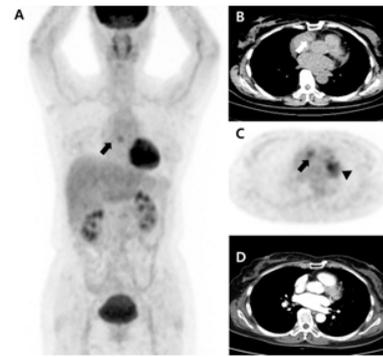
A) Maximum intensity projection image of ^{18}F -FDG PET/CT shows a focal ^{18}F -FDG uptake in mid-chest (black arrow). B, C) Axial ^{18}F -FDG PET/CT shows a nodular soft tissue lesion with mildly increased ^{18}F -FDG uptake adjacent to the right proximal aorta (white and black arrows). Focal ^{18}F -FDG uptake at left side mediastinum is physiologic uptake of left cardiac ventricle (black arrowhead). D) At the 6 months follow-up enhanced chest CT, the nodular lesion is no longer visible.
